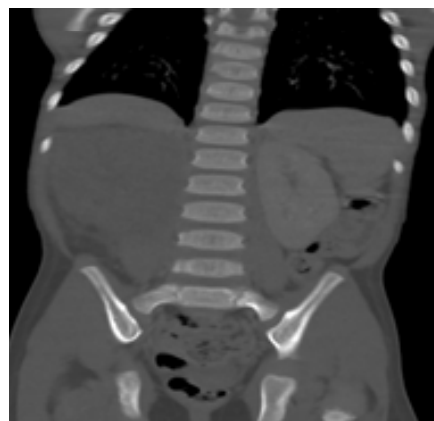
Coronal CT image (bone window) shows no lytic or sclerotic lesions in the visualised bones.
